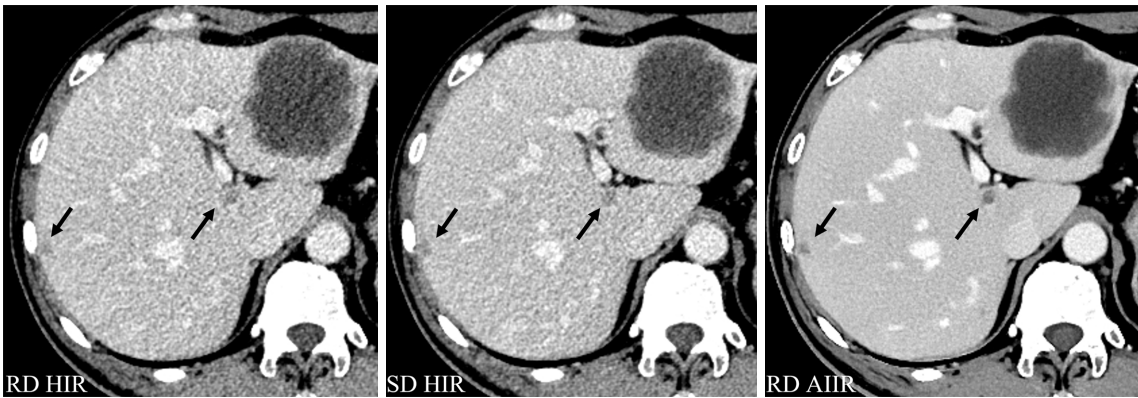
Axial contrast-enhanced CT images of the abdomen in a 51-year-old man with three liver metastases. A 65-mm lesion in hepatic segment 3 had obvious necrosis that was considered to be a large cyst by reader 1 under RD HIR. However, under SD HIR and particularly under RD AIIR, the solid components of the lesion edge could be clearly displayed. Due to the hidden location of lesions, the other two lesions (under the liver capsule of segment 5 and segment 1, black arrows) were missed by both readers with RD HIR but were detected with SD HIR and with RD AIIR. Of note, the two lesions were scored 4 with RD AIIR, which was superior to both the SD HIR scores (3 for both readers). CT, computed tomography; RD, reduced dose; SD, standard dose; HIR, hybrid iterative reconstruction; AIIR, artificial intelligence model-based iterative reconstruction.
